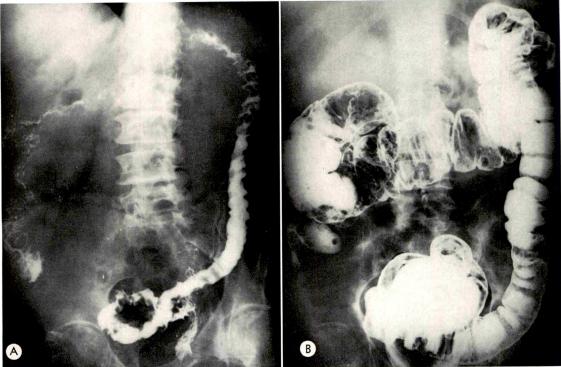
(A) Postevacuation roentgenogram of a patient with proved multiple adenomatous polyps of the colon. There is no foreshortening of the colon. (B) Filled barium enema study of the same patient. The colon appears normal apart from the polyps. This fact tends to distinguish multiple polyposis from lymphoma of the colon.
